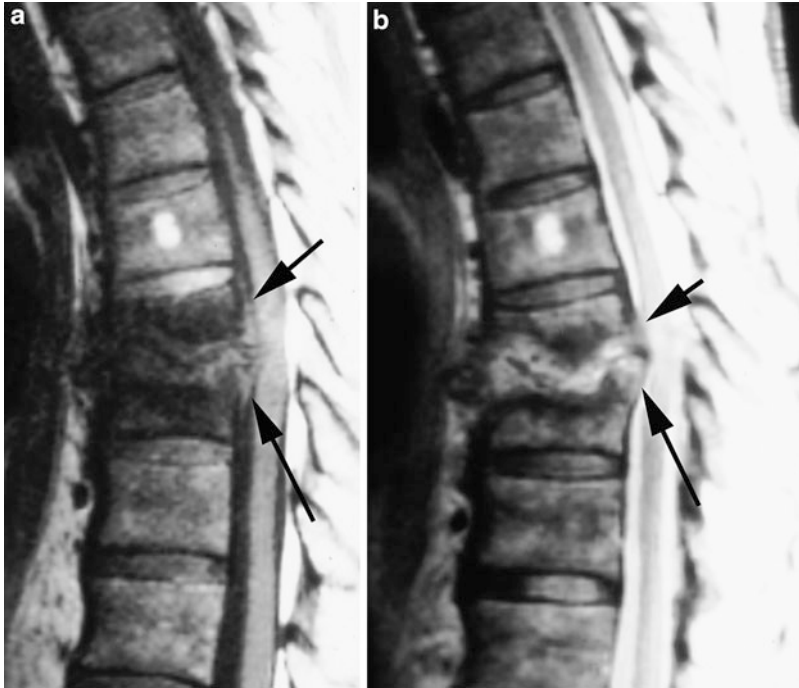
Sagittal MR of the thoracic spine demonstrating characteristic findings of diskitis and osteomyelitis, with virtual obliteration of the intervertebral disk, low signal on T1-weighted (a) and high signal on T2-weighted (b) images adjacent to the destroyed disk. Note the posterior extension of the process into the spinal canal and epidural space, causing compression of the cord
